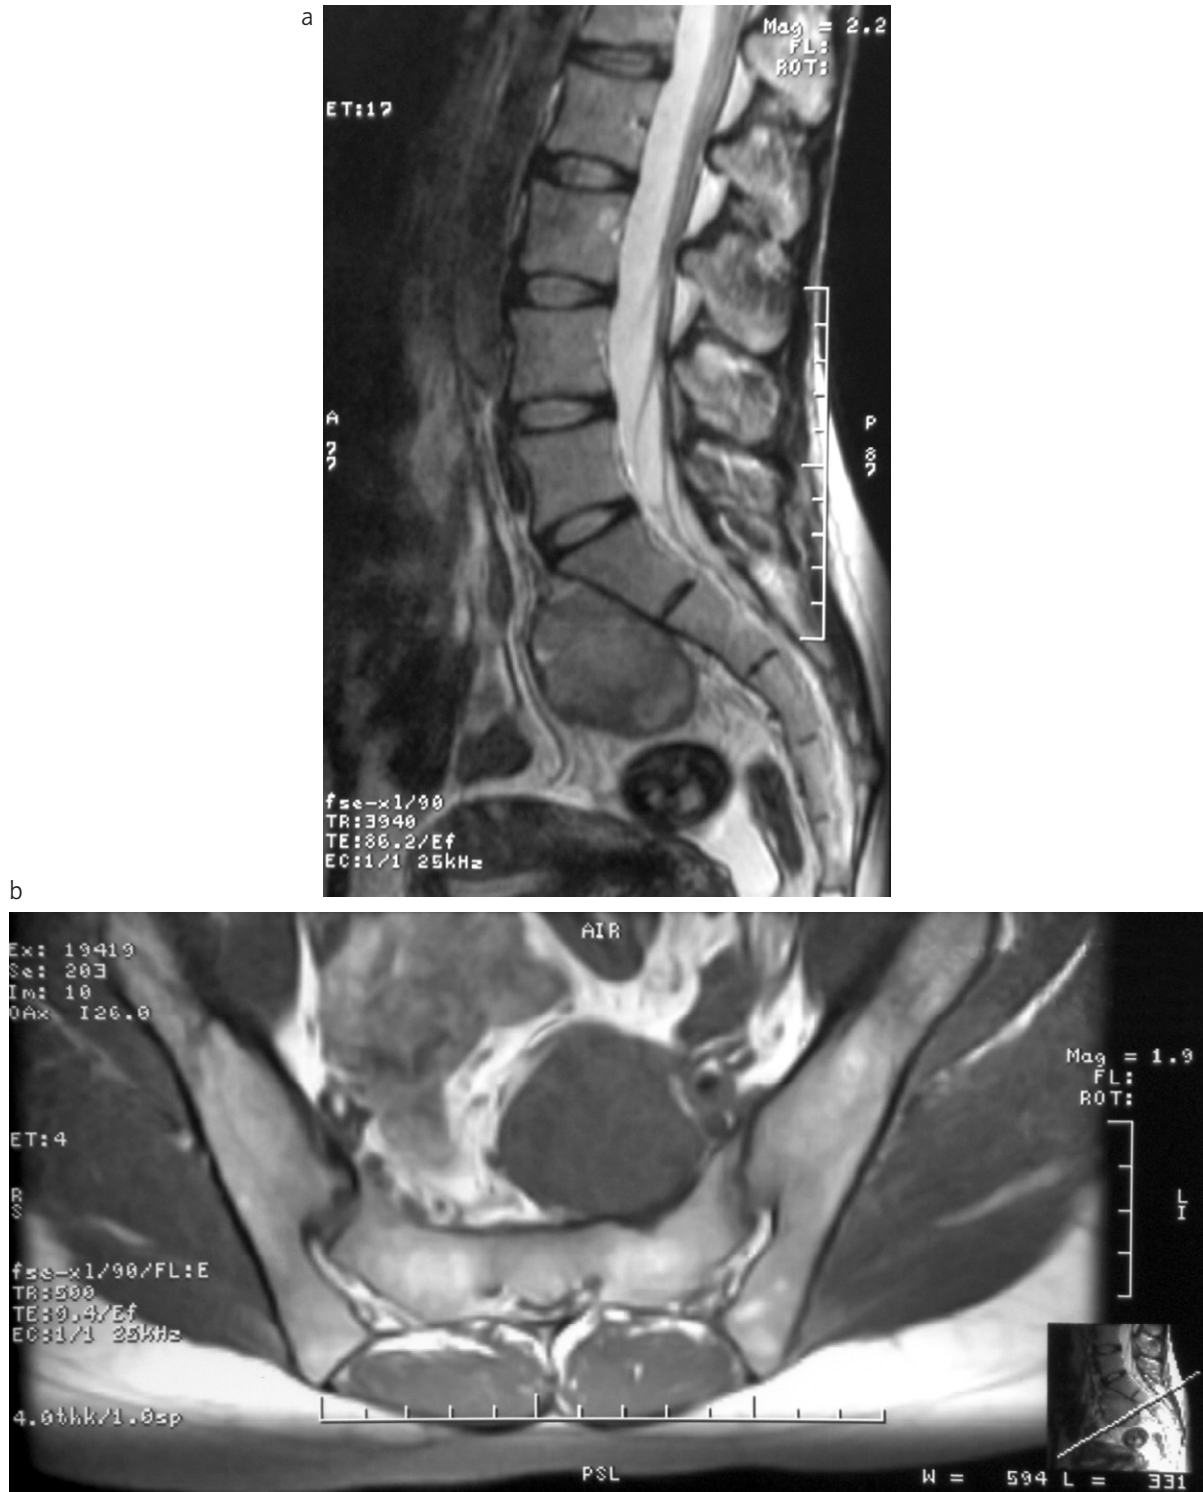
MRI in (a) sagittal and (b) axial projections presents location of the tumour in the presacral region
